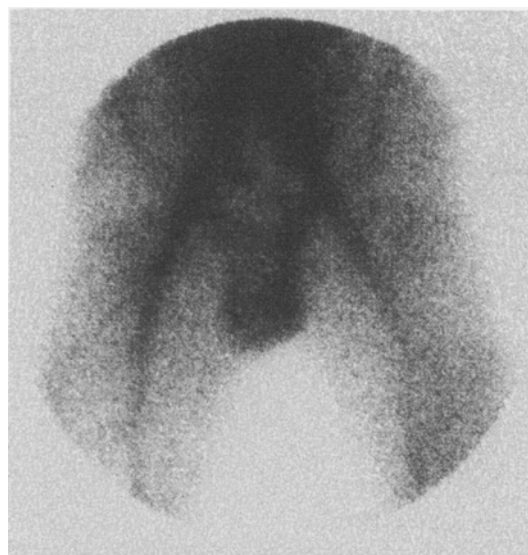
Radionuclide scrotal scintigraphy (RSS) before surgery in a boy with testicular torsion (Case 1). Typical halo-like appearance is shown in the left testicle (arrow).
